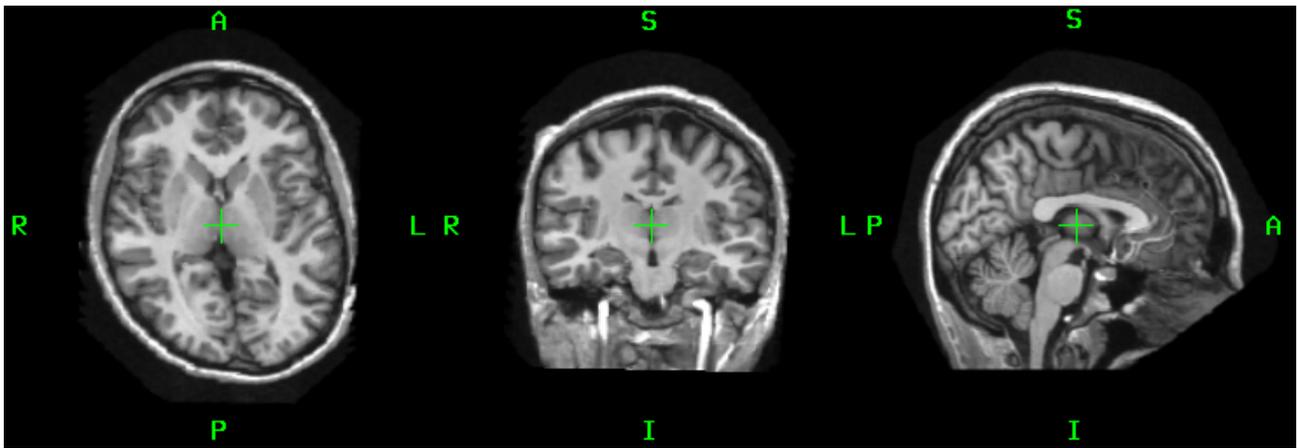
T1-weighted MR head image showing unusual occipital asymmetry
